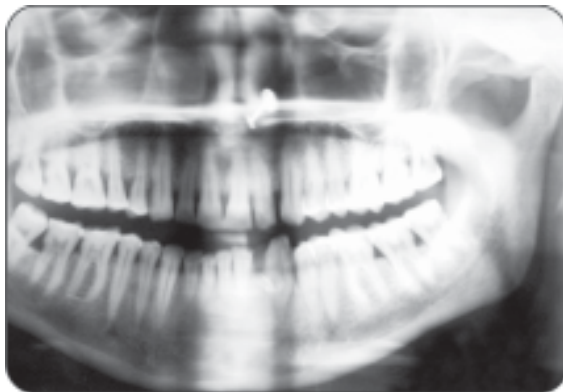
Radiograph of peripheral giant cell granuloma
